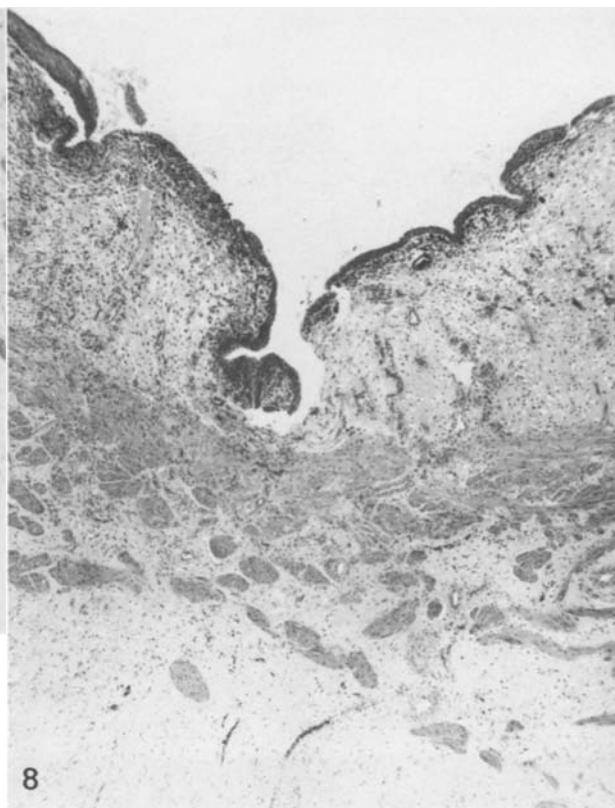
Minipig bladder wall four weeks after incision with ultrasonic scalpel. $\times 28$
